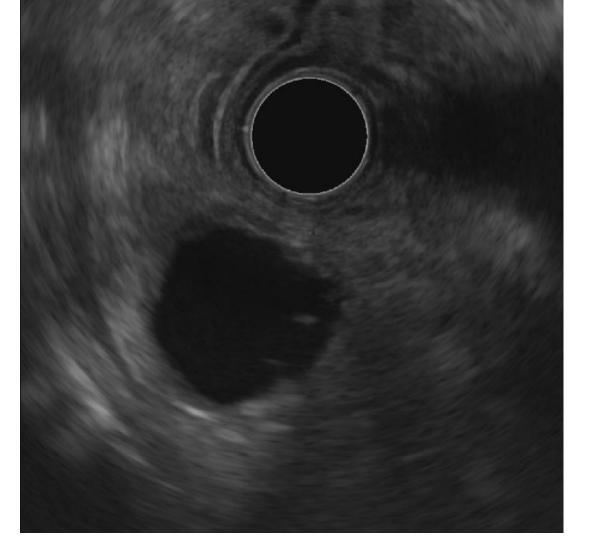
Endoscopic ultrasonography shows a unilocular cystic lesion on the pancreatic tail and hyperechoic materials inside cystic lesion.
